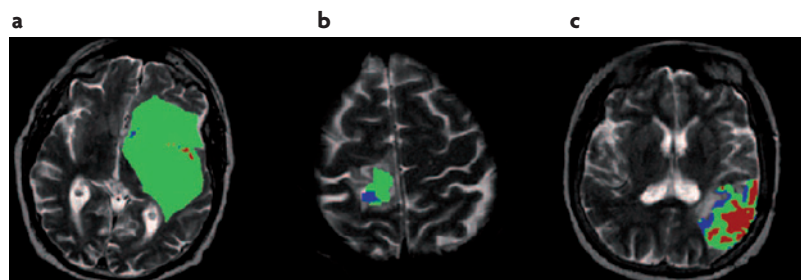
Tumour responses detected by diffusion-weighted MRI. Magnetic resonance images (MRIs) of three patients with oligodendrogliomas. The images were obtained 3 weeks into a 7-week fractionated ionizing radiation treatment. The spatial distribution of changes in the apparent diffusion coefficient of water are shown as colour overlays for patients with progressive disease (a), stable disease (b) and a patient whose tumour showed a partial response (c). The red pixels indicate areas of increased diffusion, blue pixels indicate areas where there was decreased diffusion and green pixels indicate areas where there was no change. There is a general increase in apparent diffusion coefficient in the patient whose tumour subsequently showed a partial response, defined as a 50% decrease in tumour volume observed at least 4 weeks after the conclusion of therapy and on stable or decreased dosage of steroids. Data reproduced, with permission, from REF. 99 © (2005) The National Academy of Sciences.
